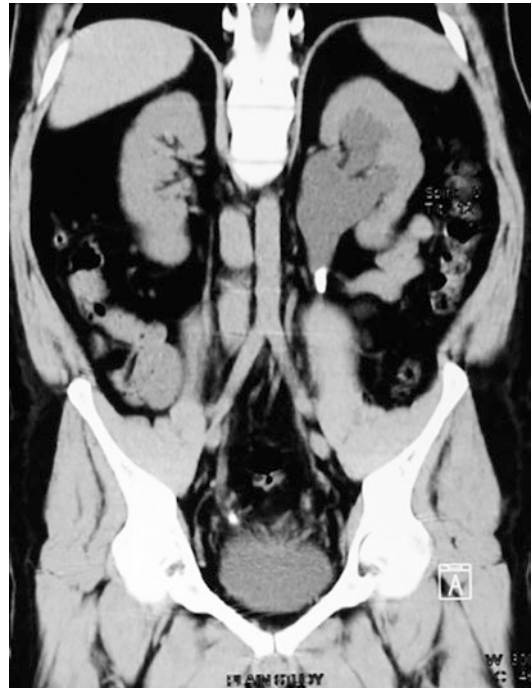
Plain CT KUB showing stone impacted at left PUJ. Stone impacted at PUJ is always a tricky situation wherein ruling out the presence of PUJO is not possible with surety without clearing the stone
